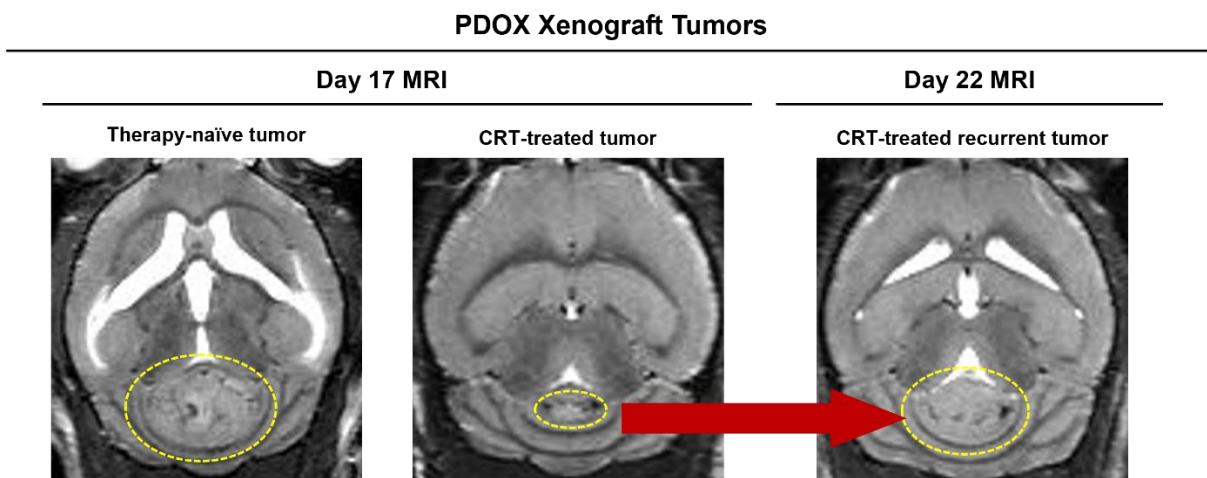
T2-weighted MRI showing therapy-naïve, CRT-treated, and recurrent tumors.
